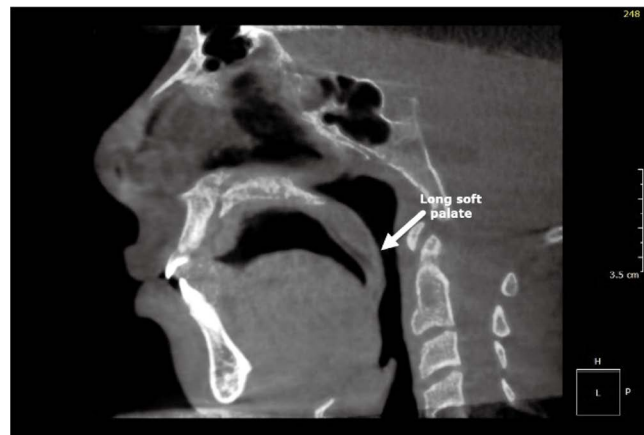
Image of a patient with obstructive sleep apnea who had a long soft palate, as seen in the midsagittal plane of a cone-beam computed tomographic scan.
